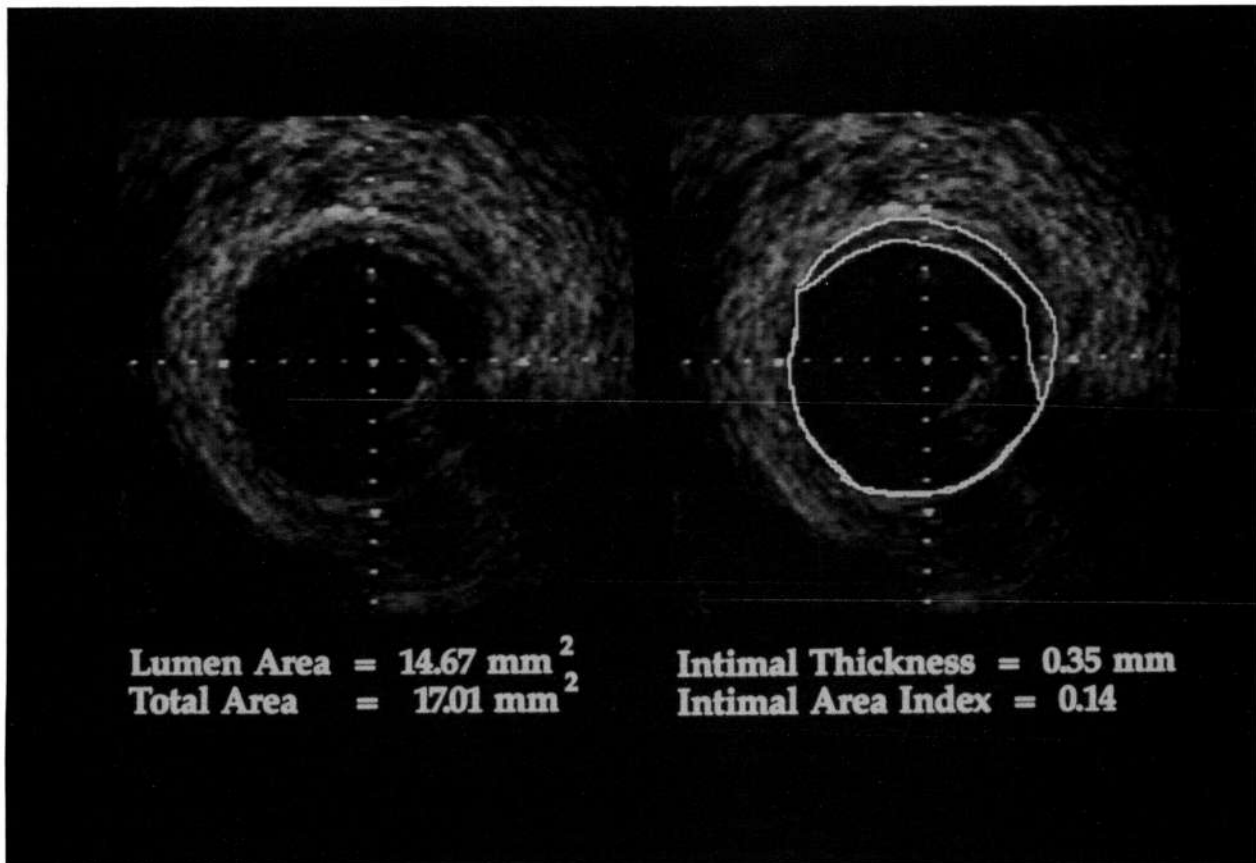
Ultrasound image from a left anterior descending coronary artery demonstrating the method of measurement of intimal thickness. The vessel-lumen interface and any intima-media interface are separately planimetered. This allows for the calculation of lumen area, total lumen plus intima area, and an intimal area index obtained by dividing intimal area by the total area.
